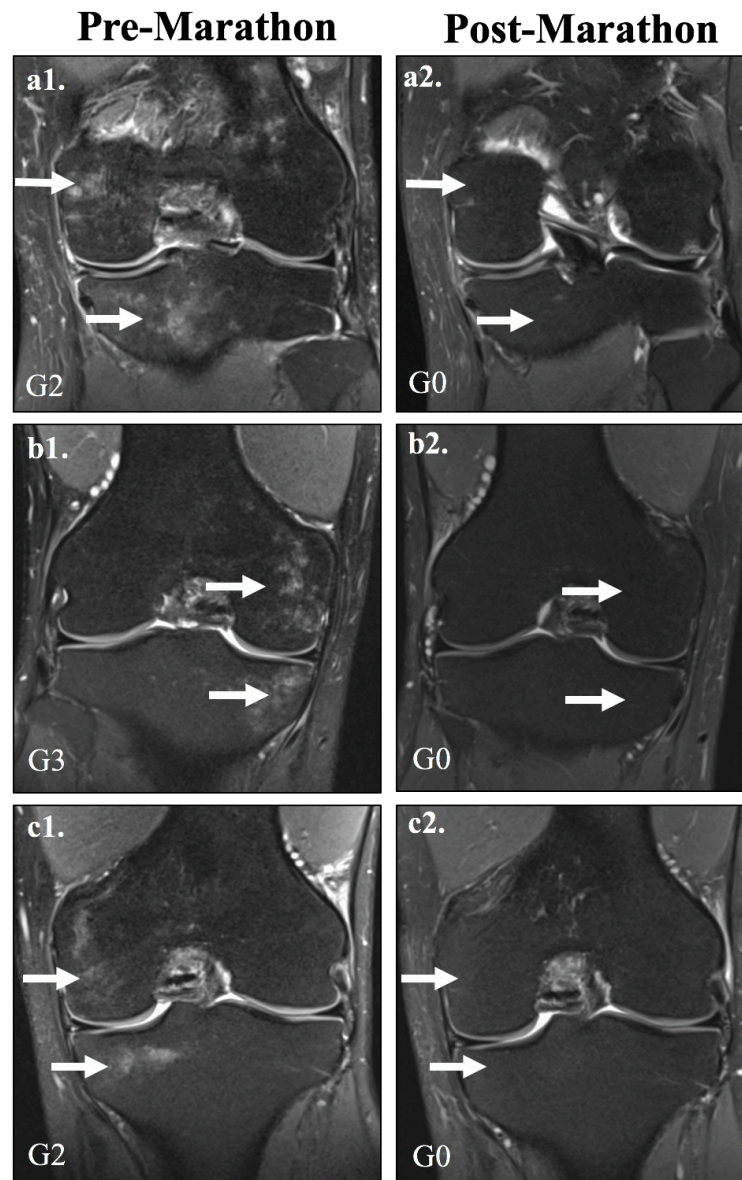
Coronal proton-density fat-saturated MR images of 3 individual knees of 3 marathon finishers (a1-2, b1-2, c1-2) presenting with complete resolution of pre-marathon BME after the marathon in the tibiofemoral compartment. The specific location of bone marrow changes is indicated by arrows (the upper arrow indicates the femoral condyle, while the lower down arrow indicates the tibial condyle). The lesion grade (G) is included in the left bottom corner, and grading was based on the KOSS, Knee Osteoarthritis Scoring System; BME, bone marrow edema.
